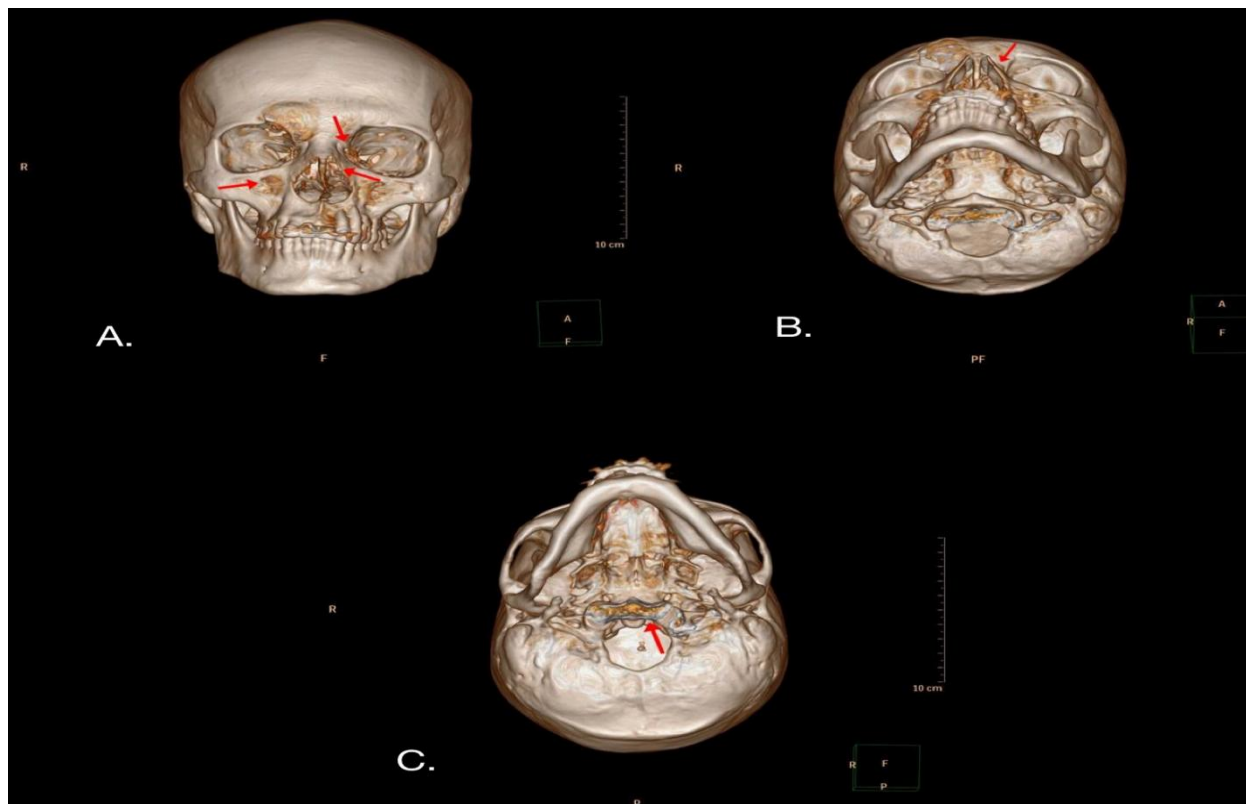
FACE CT - 3D VIEW OF PARANASAL SINUS
